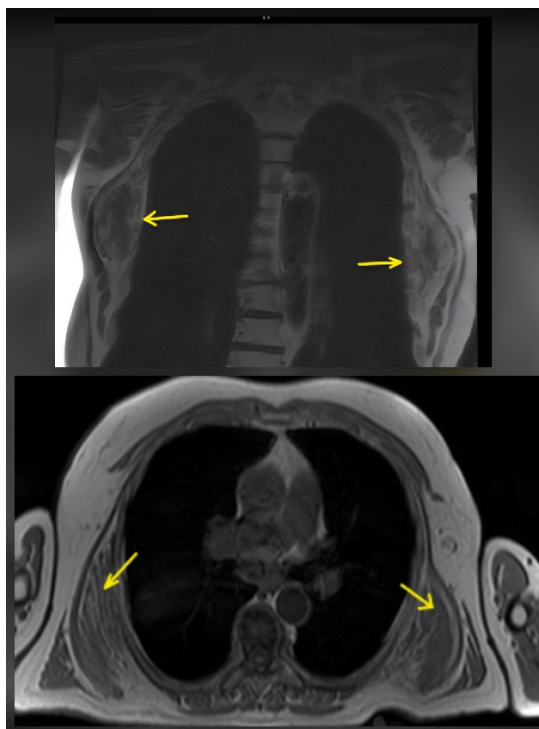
MRI of Elastofibroma Dorsi. Coronal (top) and axial T1-weighted (bottom) images without contrast demonstrate bilateral soft tissue masses interlaced with strands of fat, located deep to the serratus anterior and latissimus dorsi muscles.
